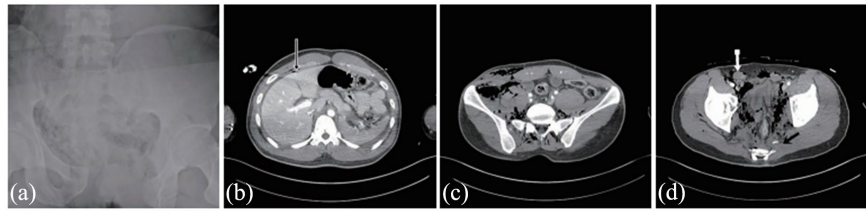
Initial radiologic assessment of the pelvic injury. (a) Anteroposterior pelvic radiograph obtained at admission demonstrating an unstable anteroposterior compression (APC type III) pelvic ring injury with marked pubic symphysis diastasis. (b) Axial contrast-enhanced computed tomography (CT) showing free intraperitoneal air (arrow), highly suggestive of associated hollow viscus injury. (c) Axial CT demonstrating extensive disruption of the pelvic floor and perineal soft tissues with emphysema extending through the pelvic compartments. (d) Contrast-enhanced CT revealing traumatic displacement of the testicle associated with active contrast extravasation (arrows), consistent with ongoing pelvic hemorrhage.
